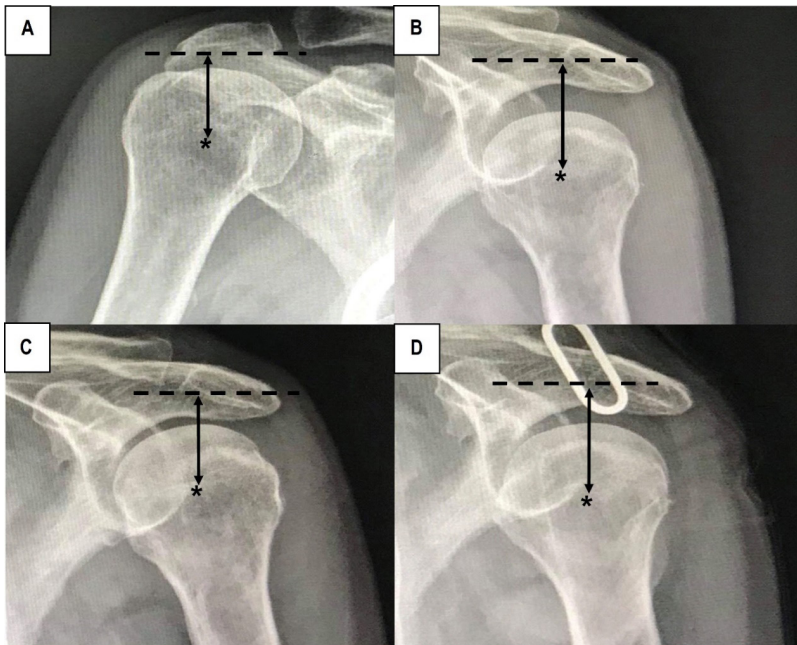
The acromiohumeral (AH) distance measurement in anteroposterior view of a shoulder radiograph: (A) normal shoulder, (B) affected shoulder without orthosis, (C) affected shoulder wearing a shoulder subluxation orthosis (SSO), (D) affected shoulder wearing a Bobath sling. In the figures, an asterisk * marks the center of the humeral head, a double arrow line represents the AH distance, and a horizontal dotted line shows the most inferolateral level of the acromioclavicular joint.
